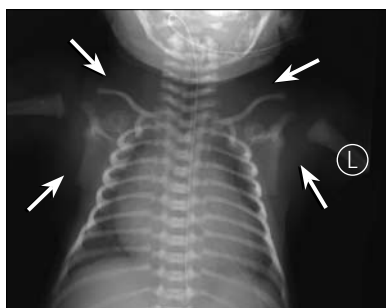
Chest radiograph demonstrates supraclavicular and axillary “fullness” and fatty density (*arrows*).
